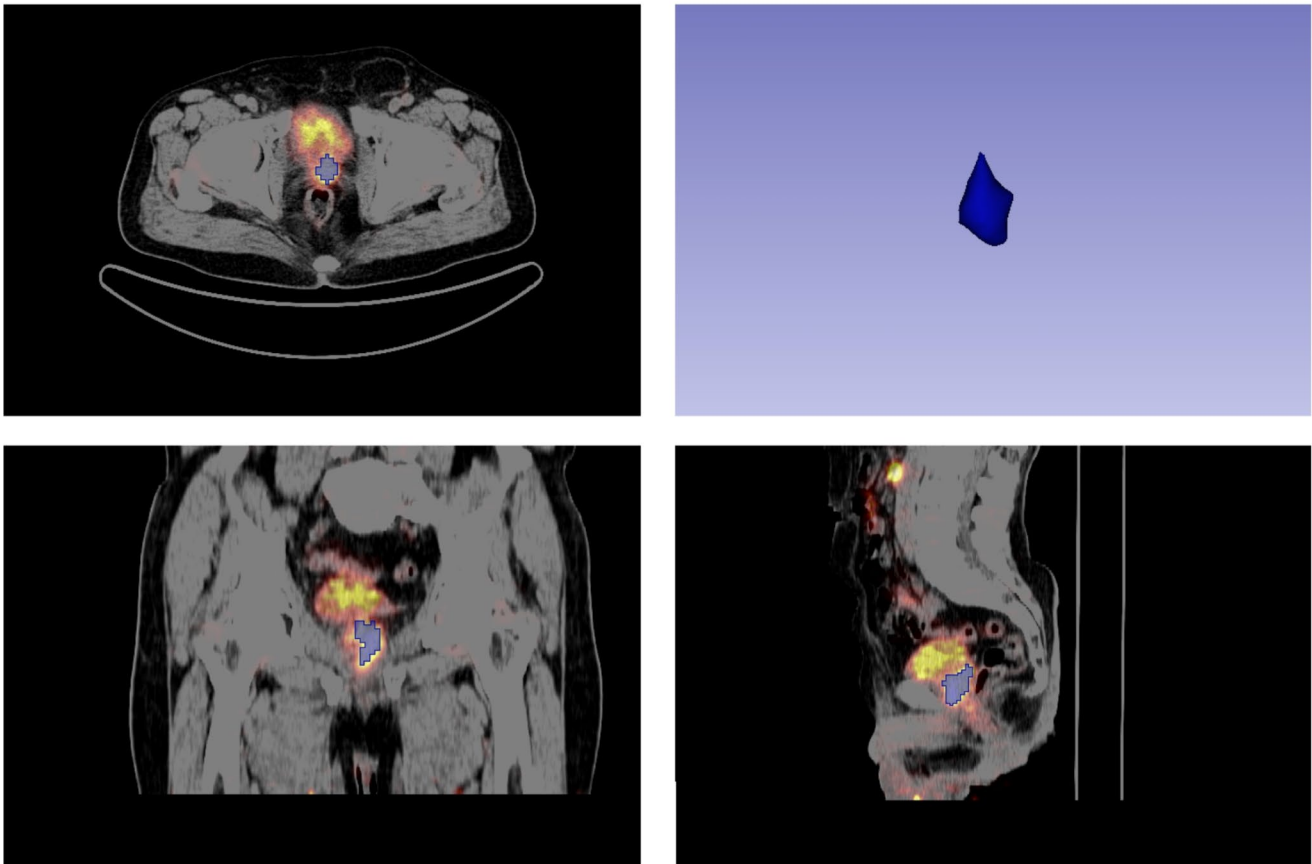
Representative example of prostate tumor segmentation from a PET/CT image using 3D-slicer software
